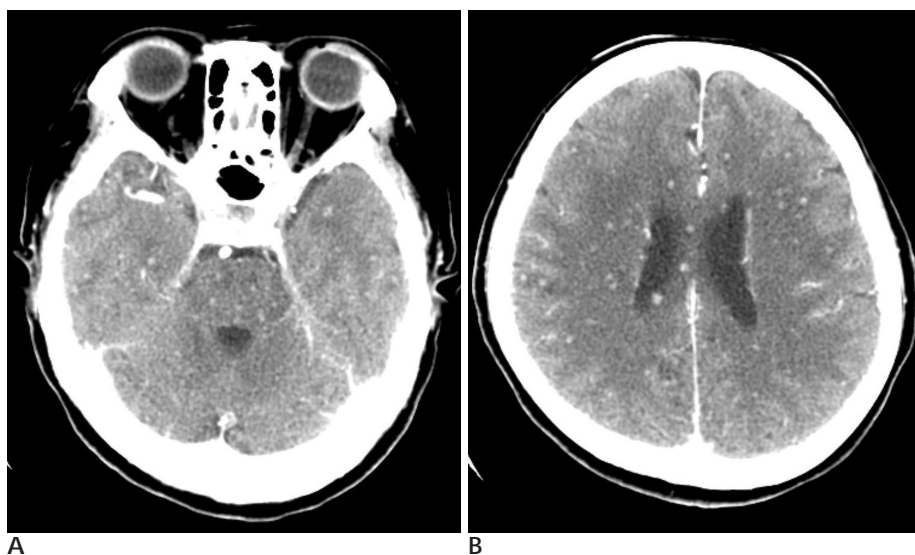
Contrast enhanced axial brain CT scans show multiple tiny enhancing nodules in the brain stem and cerebral hemisphere.
